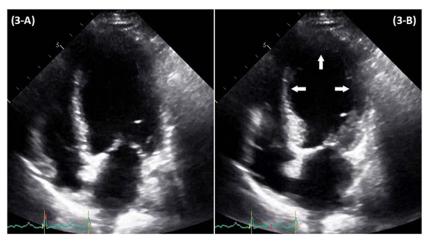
(A,B) 2-D echocardiogram showing apical ballooning (TCM).
